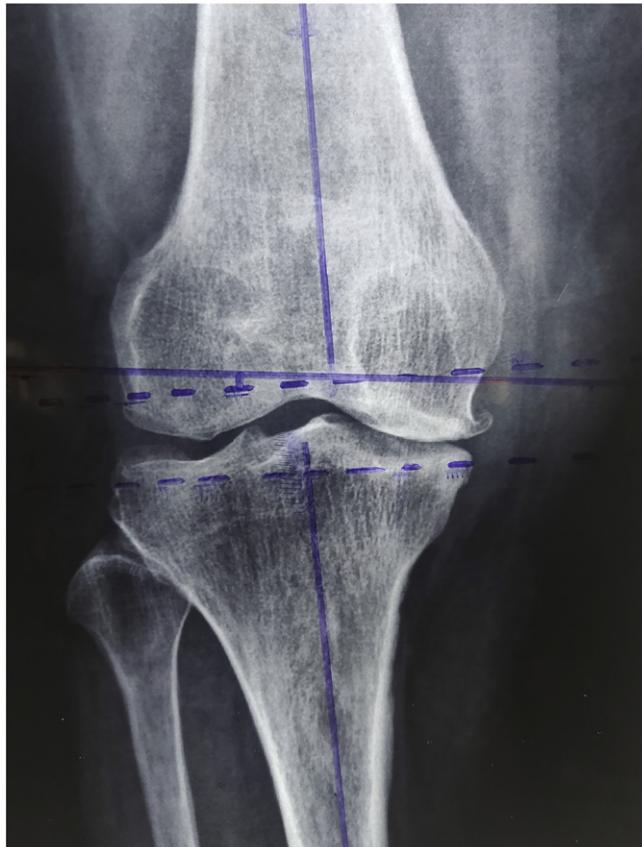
Pre-operative planning in anterior–posterior radiographs.
